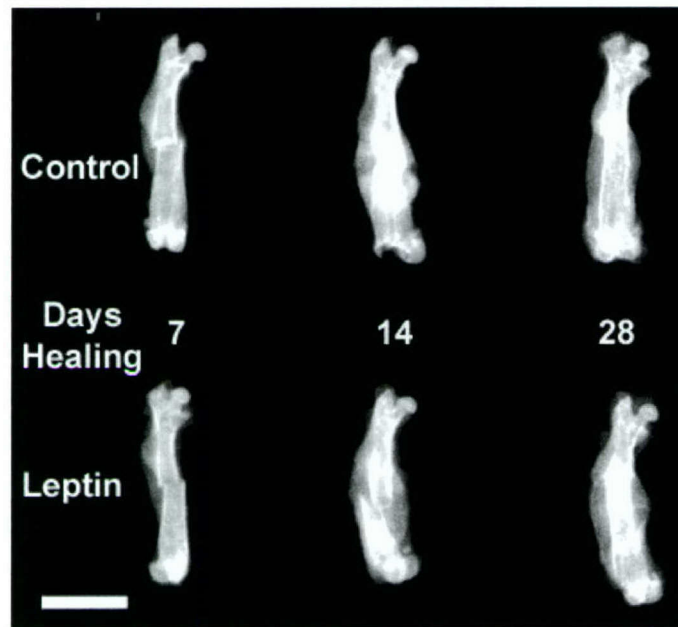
X-ray photograph comparing healing in the Leptin knockout with C57BL/6 control at 7, 14 and 28 days post-fracture. The mineralized callus appears similar in both cases, but pQCT data indicates that the Leptin fracture callus is characteristic of early fracture repair and delayed relative to the C57BL/6 control fracture callus, which is characteristic of remodeling in late healing. A lack of Leptin expression probably affects the bone formation phases of early fracture healing. Scale bar = 5 mm.
